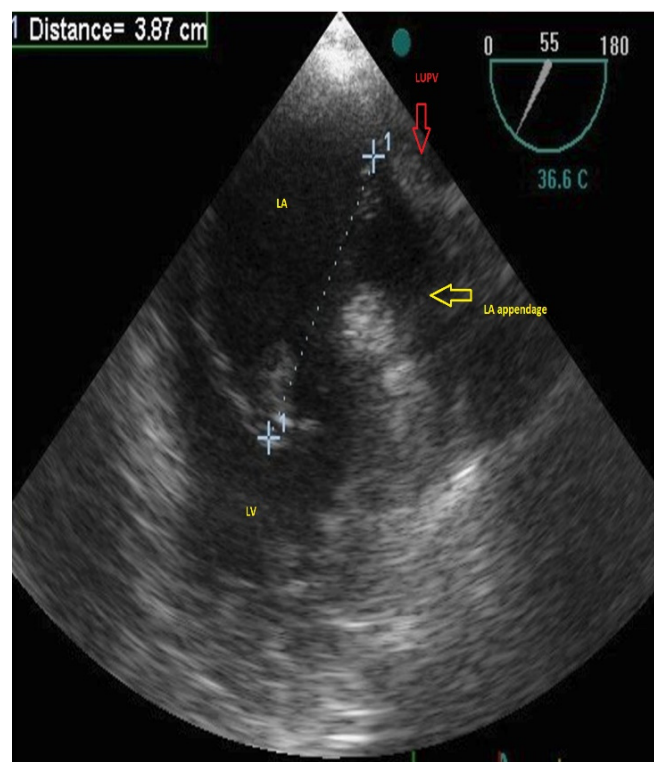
Trans esophageal echocardiography showed elongated mass originated from LUPV and protruded to LV.
